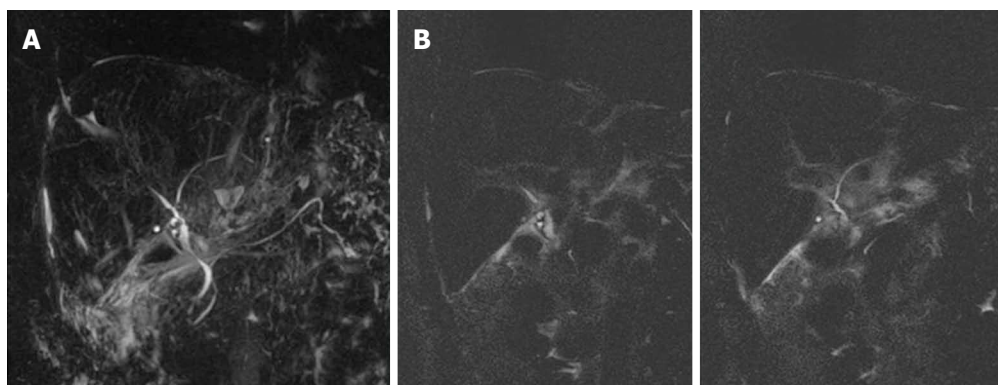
Vanishing bile duct syndrome. A: Maximum intensity projection reconstruction of 3D thin-slab fast spin-echo T2-weighted images shows only extrahepatic pre- and post-anastomotic biliary tract; the entire intrahepatic biliary system is missed; B: These findings are better appreciable on single-shot thin-slab magnetic resonance cholangiograms.
